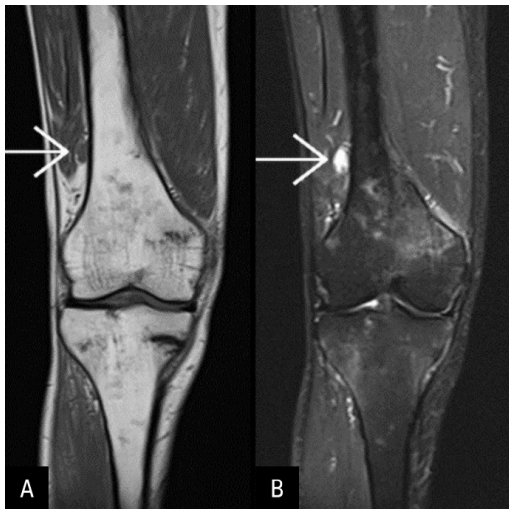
Magnetic resonance (MR) of the lower limbs. The arrow indicated the focus in the right thigh. There are also numerous speckled, low-density foci in the bone structure. A. T1-weighted imaging; B. T2-weighted imaging
